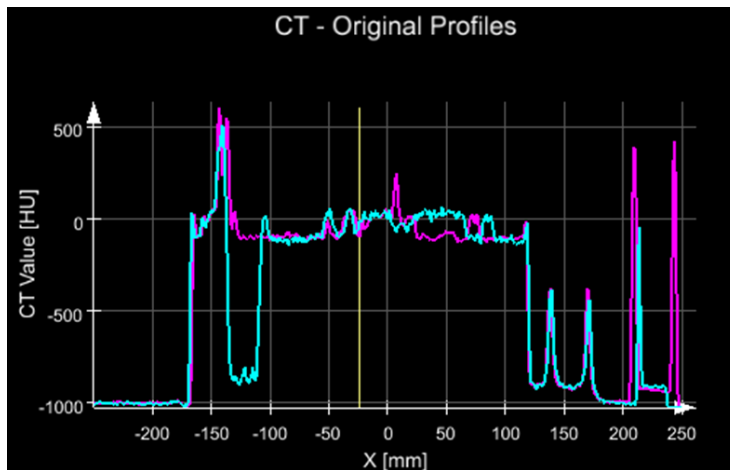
Example of patient B; variation of density given by the CT-value along the same beam path as shown in figure 4.6 (Aqua blue=planning CT, magenta= weekly CT)
